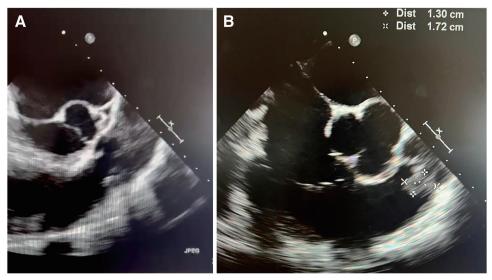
(A) Transesophageal echocardiogram showing a mass in the PA lumen. (B) Transesophageal echocardiogram showing a mass on a pulmonary valve leaflet, prolapsing in RVOT. PA: pulmonary artery; RVOT: right ventricle outflow tract
